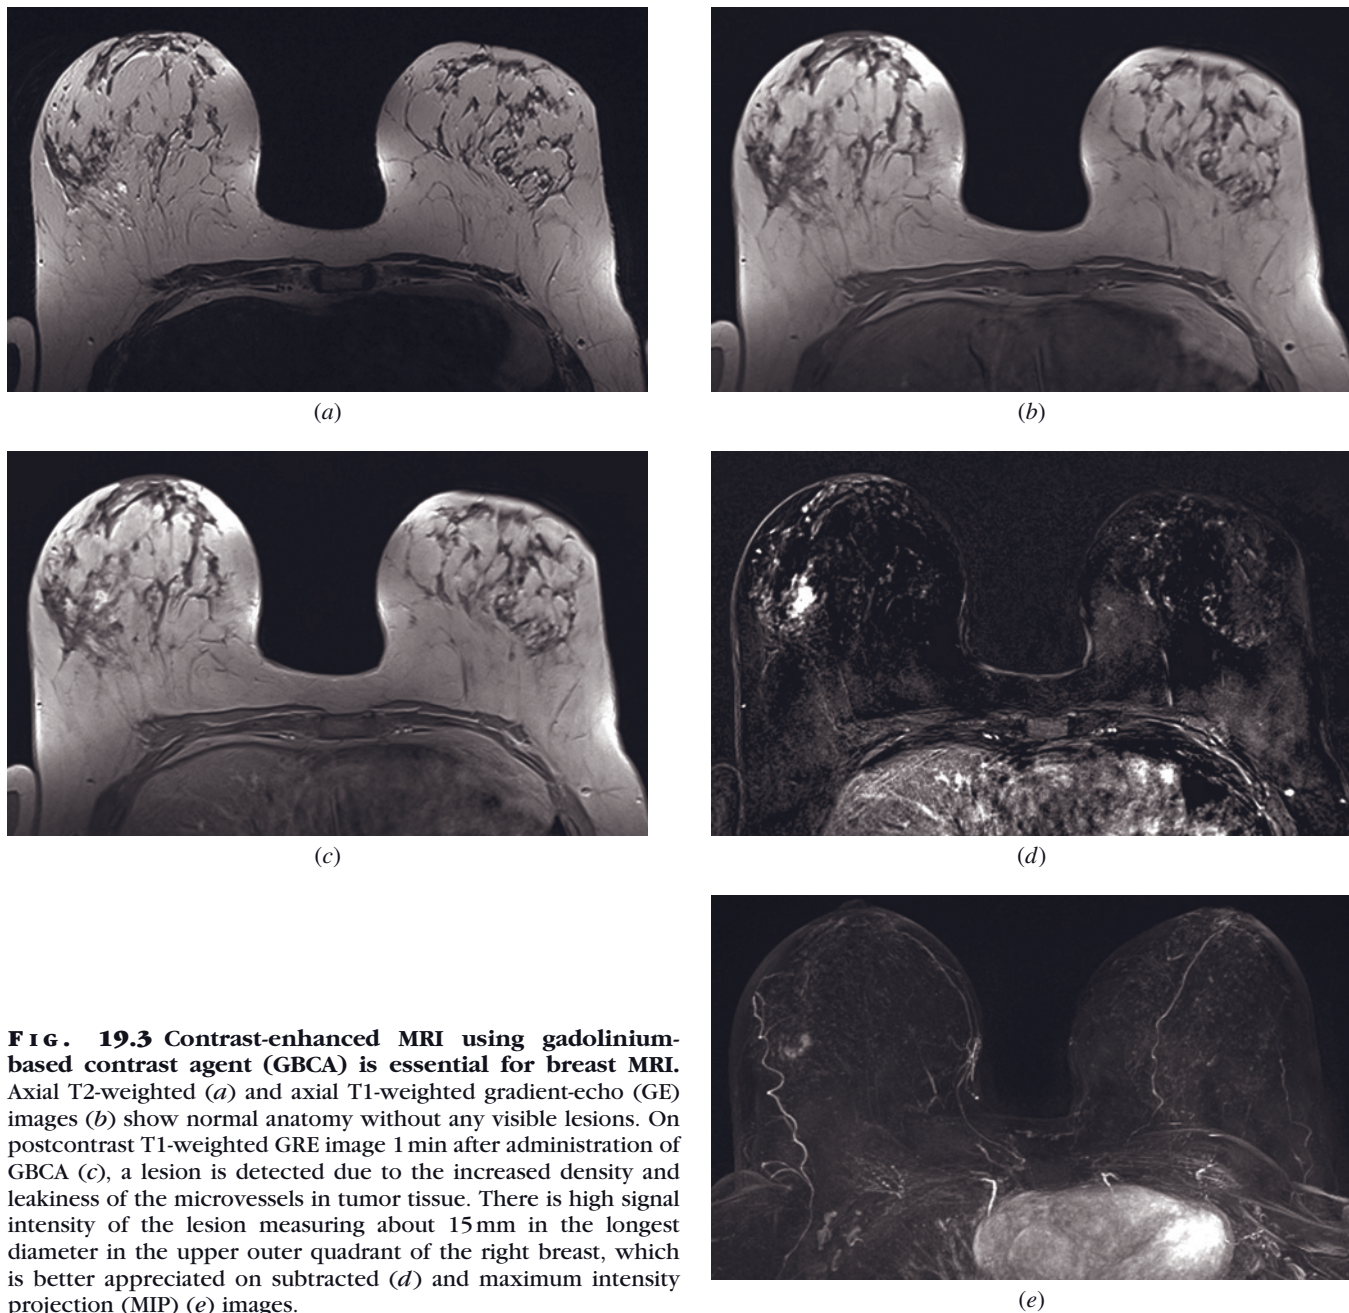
Contrast-enhanced MRI using gadolinium-based contrast agent (GBCA) is essential for breast MRI. Axial T2-weighted (*a*) and axial T1-weighted gradient-echo (GE) images (*b*) show normal anatomy without any visible lesions. On postcontrast T1-weighted GRE image 1 min after administration of GBCA (*c*), a lesion is detected due to the increased density and leakiness of the microvessels in tumor tissue. There is high signal intensity of the lesion measuring about 15 mm in the longest diameter in the upper outer quadrant of the right breast, which is better appreciated on subtracted (*d*) and maximum intensity projection (MIP) (*e*) images.
